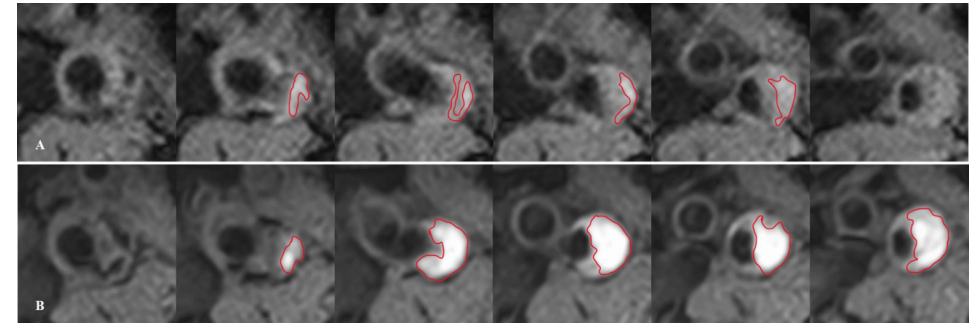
IPH progression after two 2 years' follow-up in a new antiplatelet user. 3D T1-weighted inversion recovery turbo field echo (IR-TFE) images of carotid atherosclerotic plaque with IPH at baseline (A) and follow-up (B). IPH volume (red contours) increased from 121.0 mm³ at baseline to 250.6 mm³ after 2 years of follow-up (107% increase). IPH= intraplaque hemorrhage
